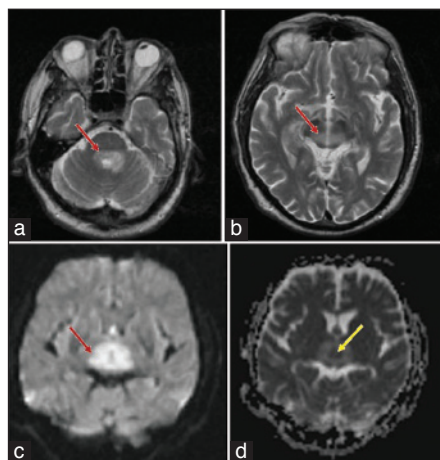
T₂WI showing edema in the dorsal pons (a) and midbrain (b). Lesion is hyperintense on diffusion-weighted imaging (DWI) (c) and shows restricted diffusion in apparent diffusion coefficient (ADC) maps (d). Yellow arrow points to the lesion and red arrow to the edema surrounding
